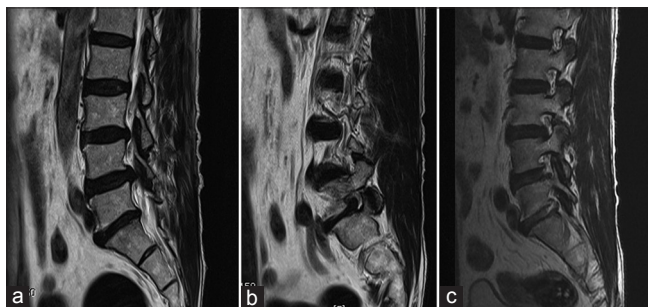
Preoperative magnetic resonance images (MRI) show posterolateral type L4-L5 disc herniation and foraminal type of L5-S1 disc herniation (a and b). Postoperative MRI show herniated disc materials removed simultaneously, and L5 exiting nerve root decompressed successfully (c)
